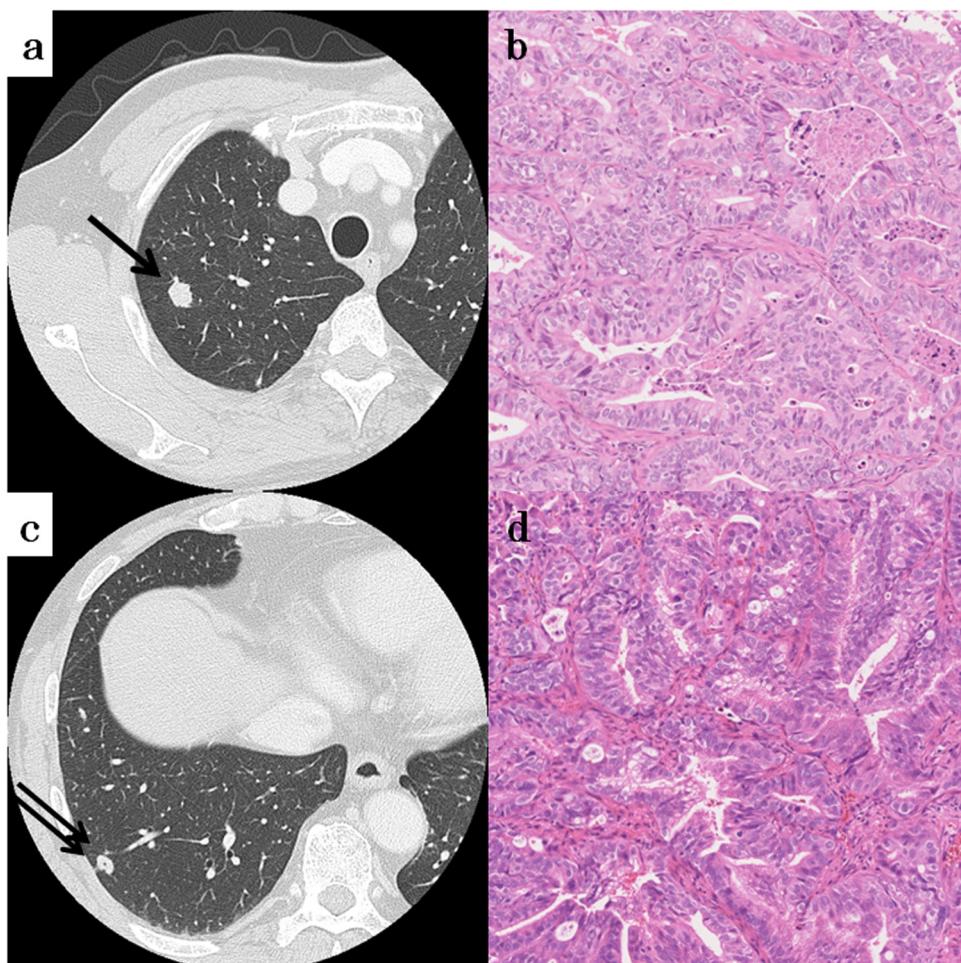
Chest computed tomography revealed a 1.2-cm nodule in the right upper lobe (a, single arrow) and 0.9-cm nodule in the right lower lobe (c, double arrows). On pathological examination, each lesion was identified as a moderately differentiated adenocarcinoma (b, d).
